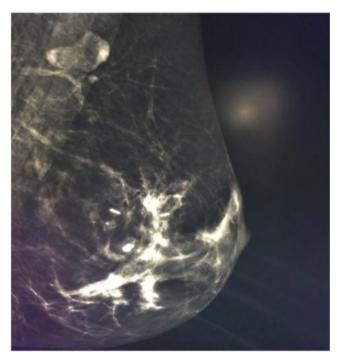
Mammography of patient 3 shows areas of micro-calcifications marked by iodine-125 seed. No radiographically suspicious area was identified in the region posterior to the marked area.
